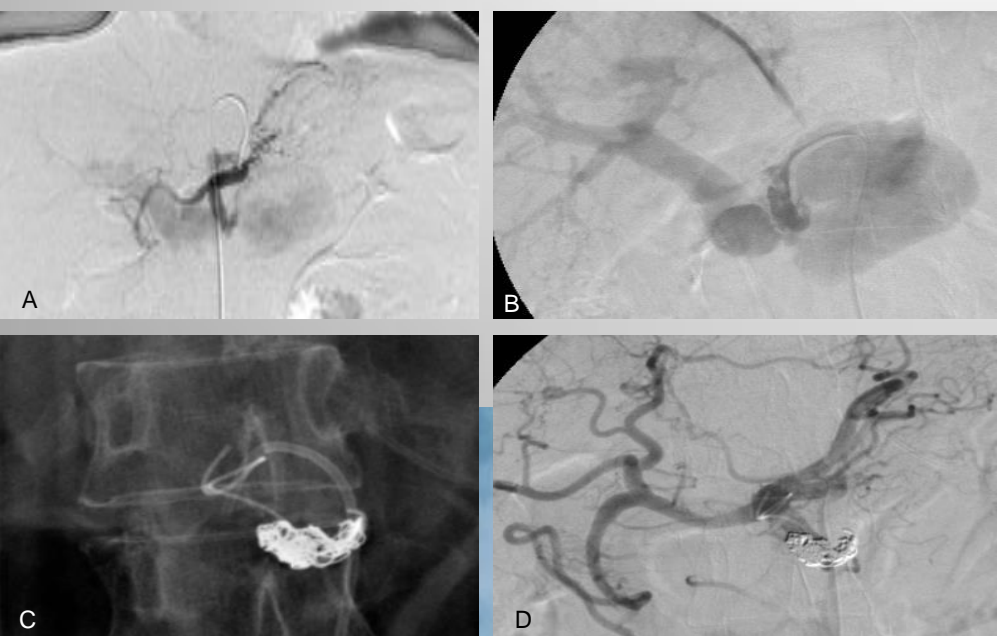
(A) Celiac arteriography demonstrated a splenic artery pseudo-aneurysm and immediate opacification of the distal splenic vein and portal vein. (B) Celiac arteriography performed two days later shows Axial CT image before pancreatectomy shows enlarged size of the pseudoaneurysm. (C) Coil embolization of arterial segments proximal to the pseudoaneurysm. (D) Celiac arteriography after TAE reveals no opacification of the pseudo-aneurysm or splenic vein.
